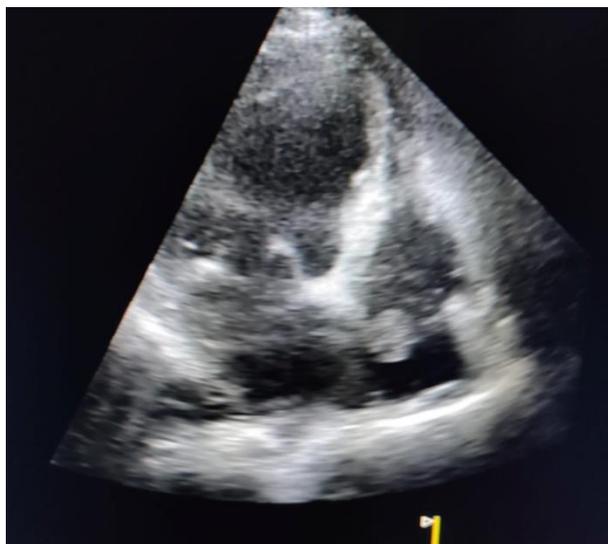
Transthoracic echo image of myxoma
